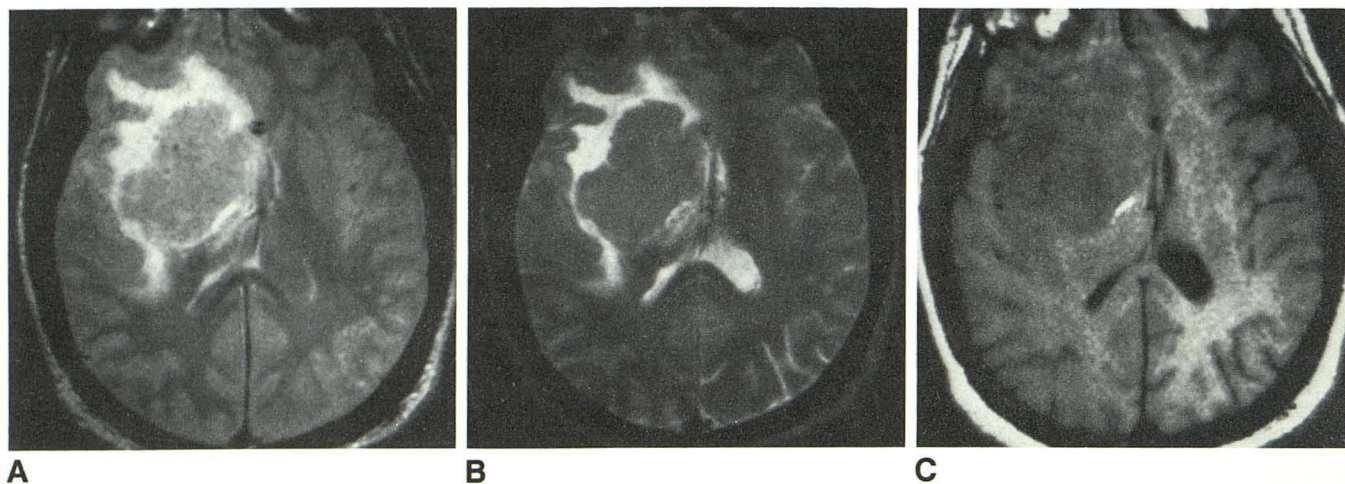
A–C, Case 5. 60-year-old man with lymphoma in right deep white matter and basal ganglia. Proton density and T2-weighted images, 3000/30, 80 (A and B), 600/20 (C), show a large, slightly hyperintense lesion relative to gray matter with mild edema and mild mass effect for the lesion size. On the T1-weighted image, tumor and edema are slightly hypointense relative to gray matter.
